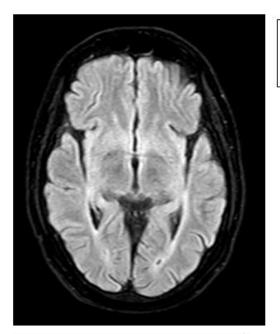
Axial non-contrast MRI Brain showing diffuse bilateral cerebral and cerebellar atrophy.
